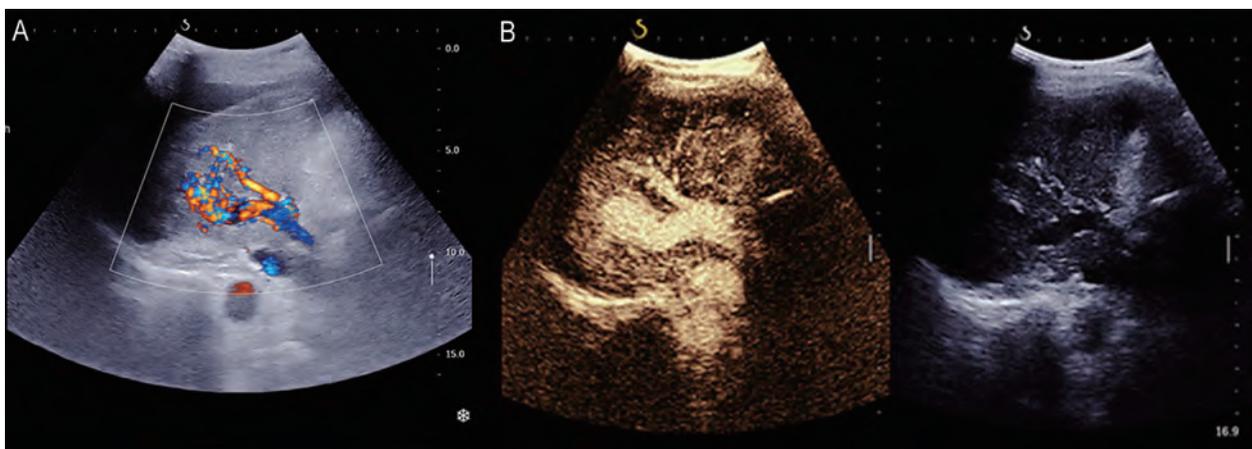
Ultrasound image showing HAPFs under Doppler (A) and Sonovue contrast (B). HAPF, hepatic arterioportal fistula.
